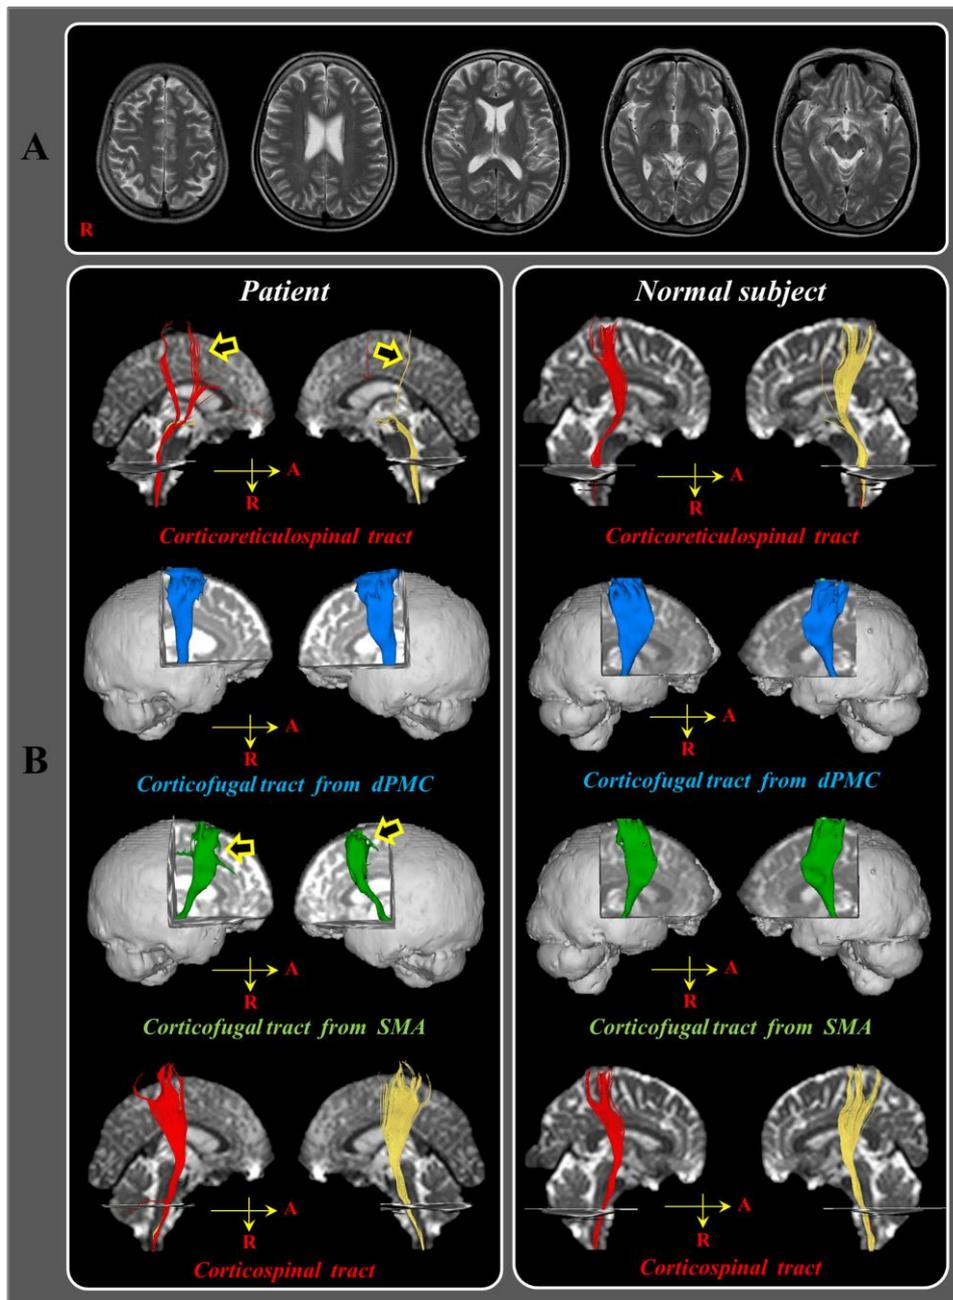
A. T2-weighted brain magnetic resonance images at three months after onset show no abnormality. B. On three-month diffusion tensor tractography, partial tears (arrows) of the corticoreticulospinal tract and the corticofugal tract from the supplementary motor area of the subcortical white matter are visible in both hemispheres, whereas the integrity of the corticospinal tract is preserved in both hemispheres.
